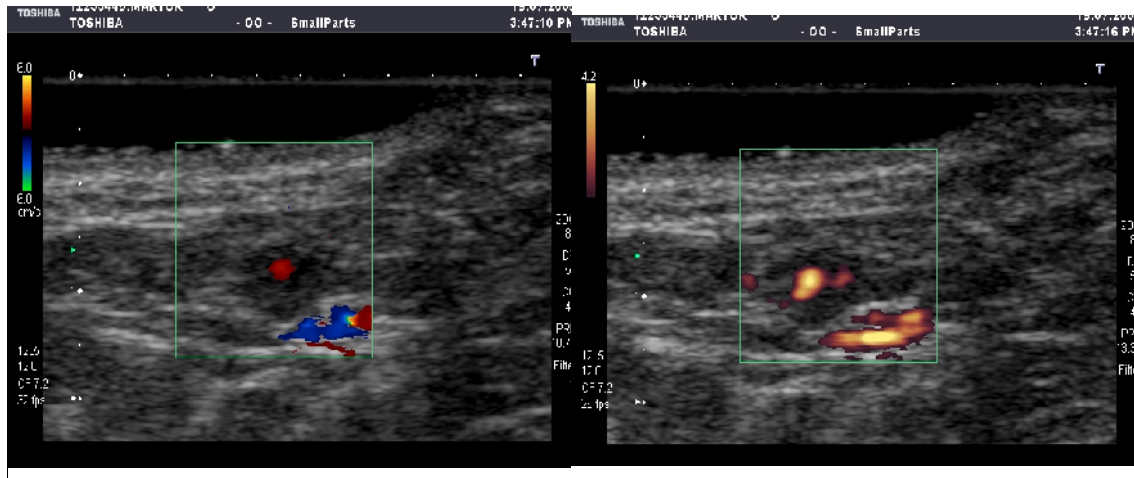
Doppler color image of axillary lymph nodes
